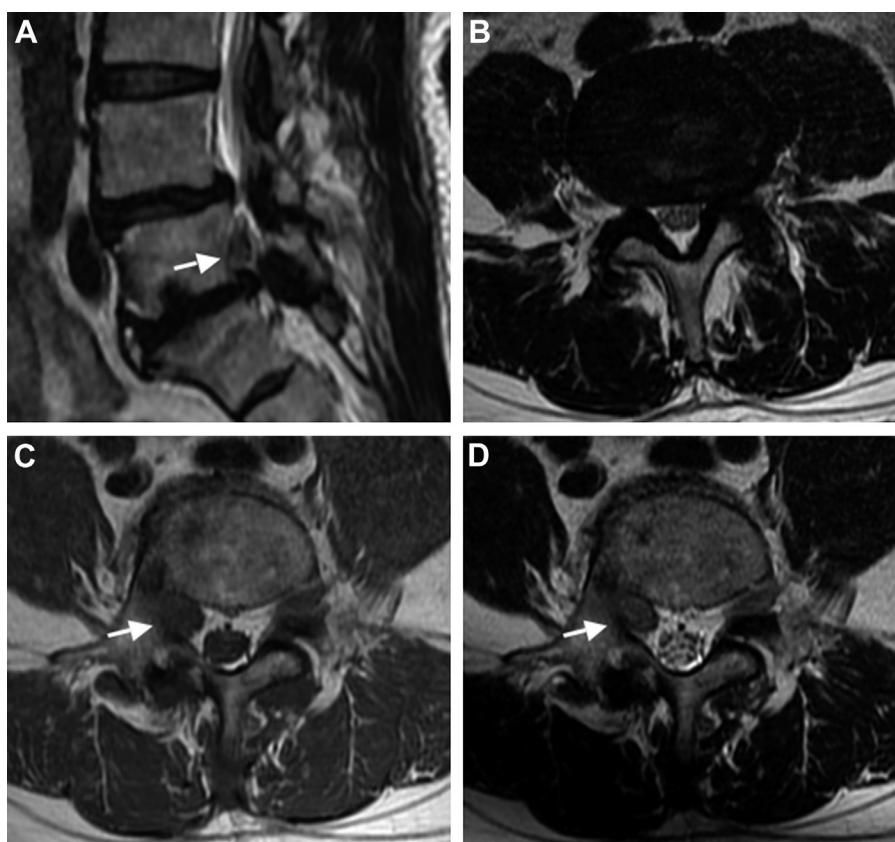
Magnetic resonance imaging indicating a right-sided intraspinal mass-like lesion at the level of L5 (arrow). (A) Sagittal T2-weighted images; (B) axial T2-weighted images at the L4–L5 intervertebral level showing lateral recess stenosis because of hypertrophied ligamentum flavum. (C) Axial T1-weighted images at the L5 pedicle level; (D) axial T2-weighted images at the L5 pedicle level.
